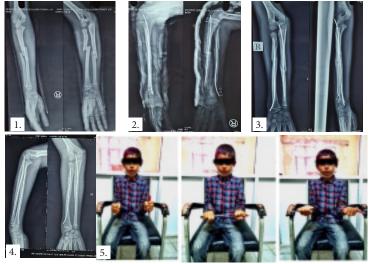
1. Pre-operative radiographs (Lateral and AP) 2. Immediate post-operative radiographs (Lateral and AP) 3. Radiographs at six
